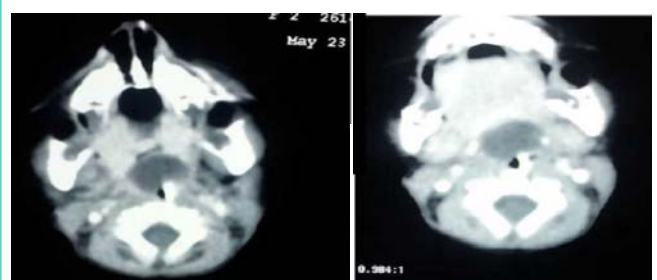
Computed tomography scan of neck showing cystic lesion 3x3 cm in the vallecula.
